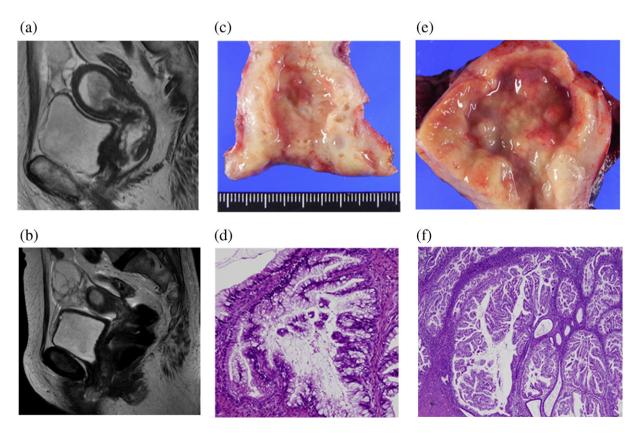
Magnetic resonance imaging and resected uterus findings. (a) Multiple cystic lesions along the cervical canal. (b) Ovarian tumor and external urethral meatus neoplasm. (c) Enlarged cervical canal with multiple cysts on the wall. (d) Mucinous adenocarcinoma of the cervix. (e) Diffused tumor of the endometrium. (f) Noninvasive mucinous metaplasia of the endometrium.
